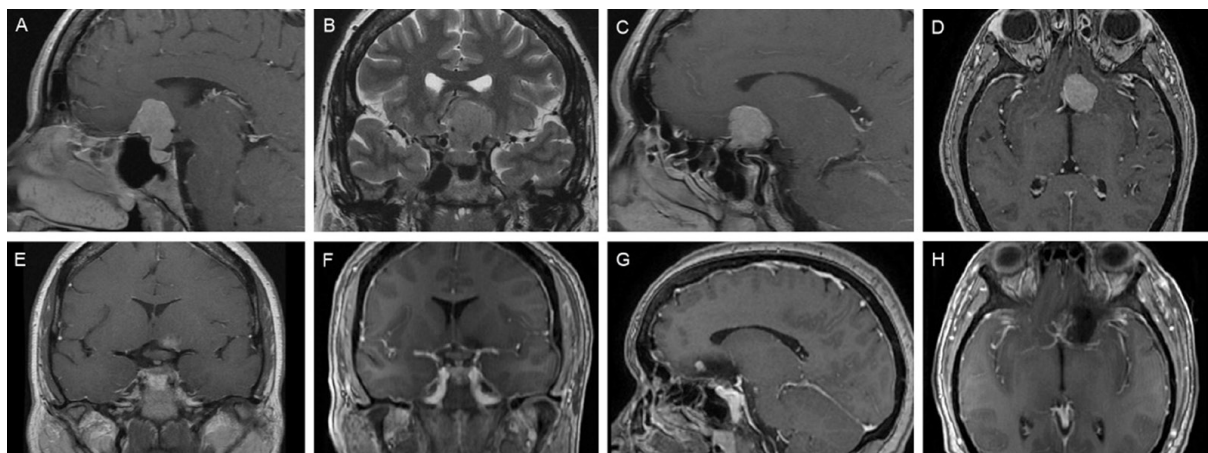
Pre- (A-E) and postoperative (F-H) magnetic resonance images in a case of tuberculum sellae meningioma excised via an endoscope-controlled keyhole supraorbital approach. Extension beyond the internal carotid on the left and anterior cerebral artery encasement on the right led to selection of endoscope-assisted keyhole transcranial approach instead of an extended endoscopic endonasal transsphenoidal approach
